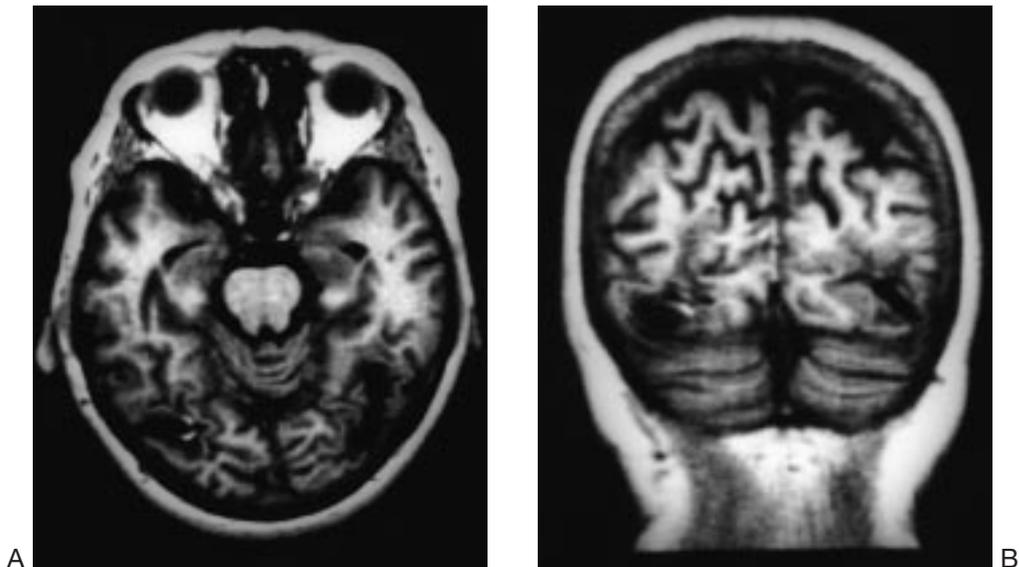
T1 weighted MRI showing a left-sided lesion tying across the temporo-occipital sulcus and a right-sided lesion centred on the middle occipital gyrus.
